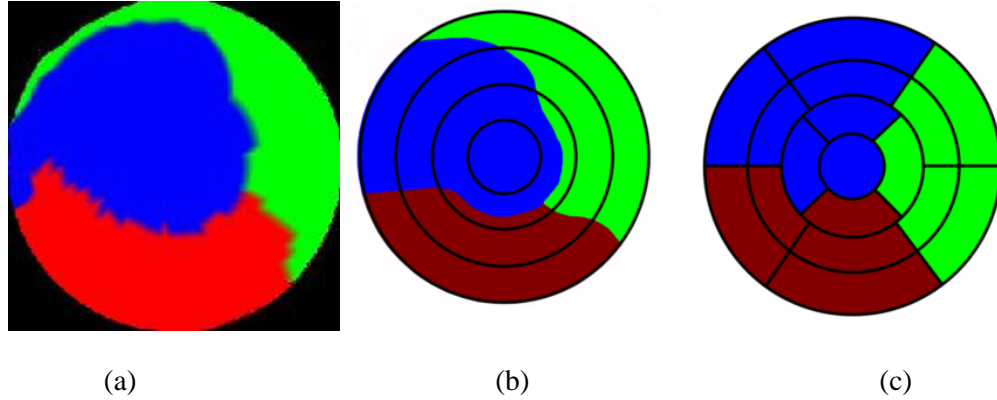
Comparison of our CT-derived model for patient 4 (a) with the Green Lane (b) and the 17-segment model (c). The black concentric lines drawn in figure (b) have been placed for comparison purposes.
